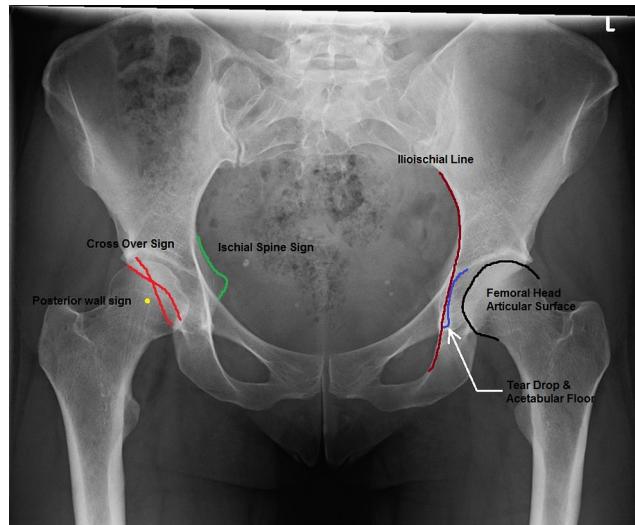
Standing AP pelvis X-ray, showing Cross over (red), Ischial spine (green), and Posterior wall sign (yellow) in right hip. Left hip shows normal relationship of ilioischial line (maroon), acetabular floor (blue) and femoral head articular surface (black).
